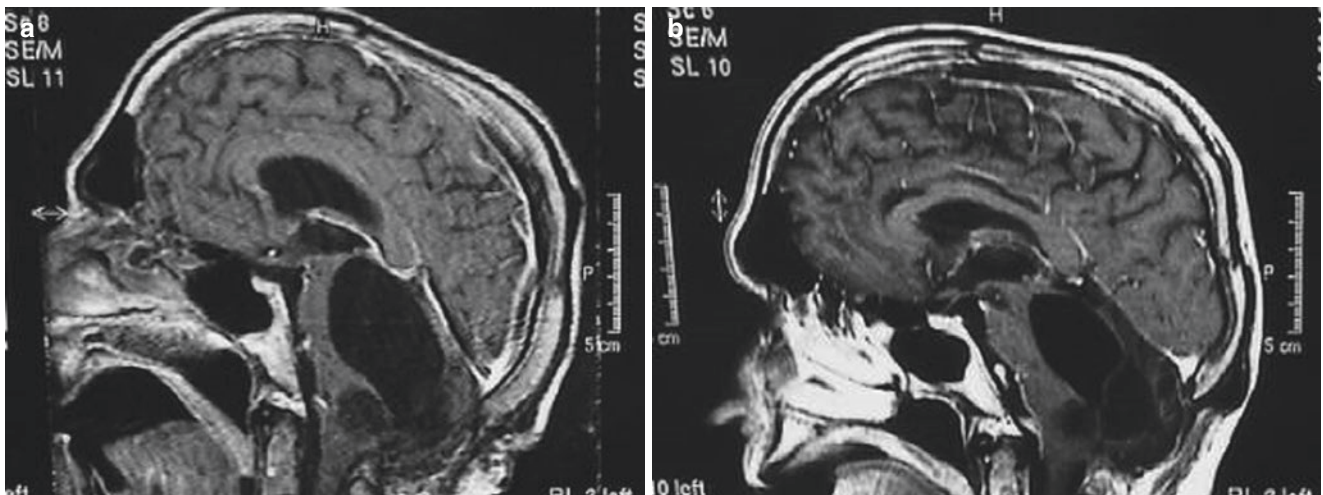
(a) Pre-endoscopic magnetic resonance imaging (MRI), showing the entrapped fourth ventricle as a complication of microsurgical removal of an epidermoid cyst; (b) post-endoscopic MRI, showing
